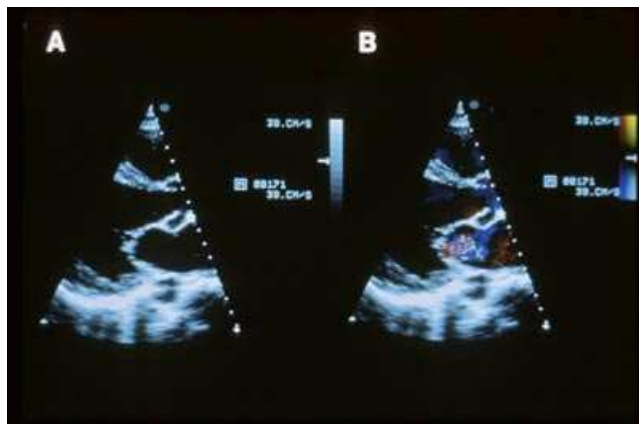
Parasternal long-axis view of two-dimensional echocardiogram (panel A). The color is switched on (panel B) revealing the mitral regurgitant jet. A variance map is used.
